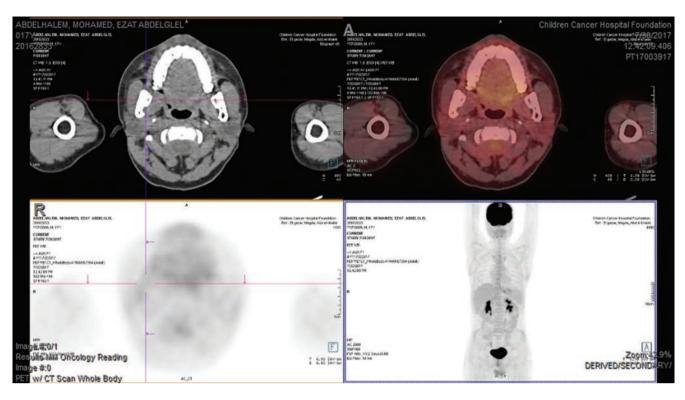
Axial and MIP images of PET/CT and fused ¹⁸F-FDG-PET/CT images of the mentioned patient at W18 showing complete metabolic remission of the involved mandibular lesion
